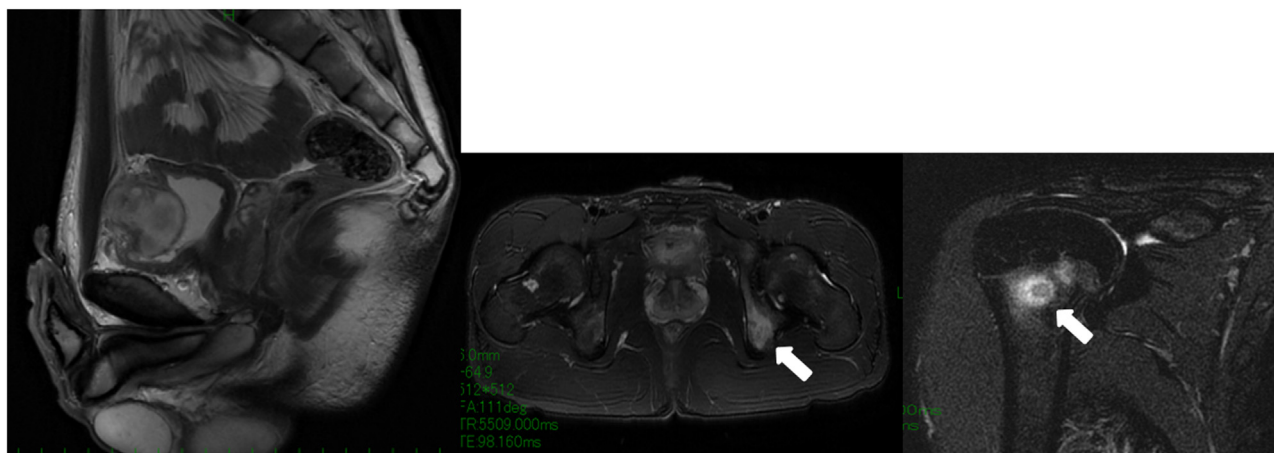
Left, Sagittal T2-weighted MRI showed a mass measuring 5 cm in diameter at the urinary bladder dome with extramural invasion. Middle, The left ischial bone presented high intensity on axial T2-weighted image. Right, Coronal T2-weighted imaging showed local high-intensity area in the right humerus.
